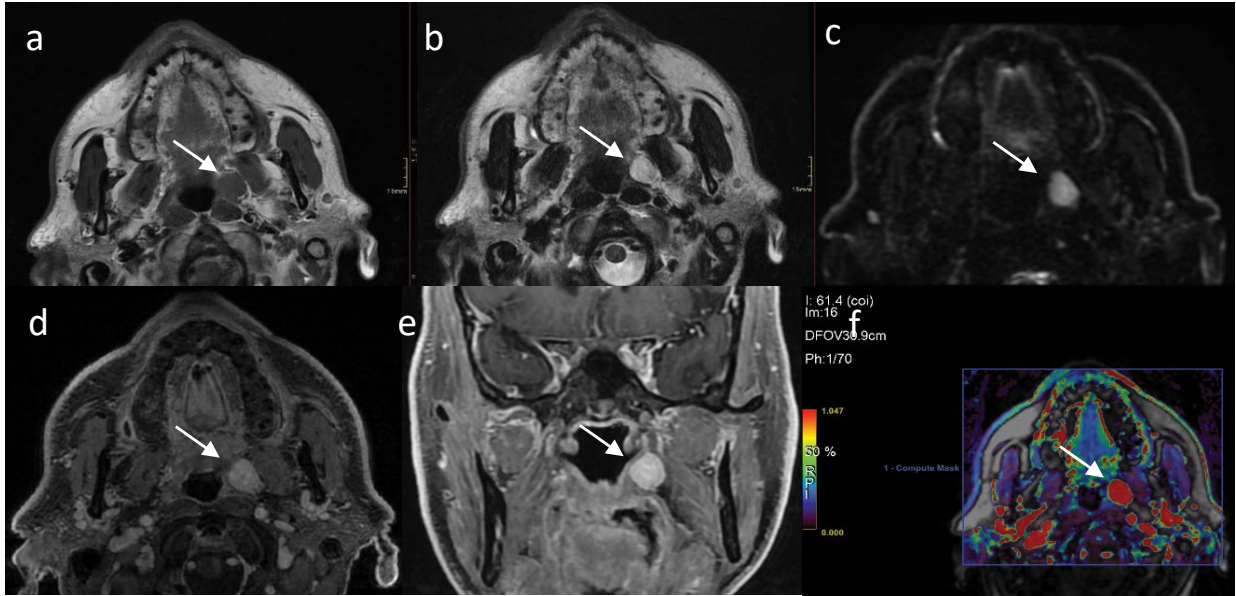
MRI of 66-year-old man. Findings: MRI shows a lesion into the left parapharyngeal space with an expansive growth, with isointense signal on T1 to muscle, hyperintense on T2, with restricted signal on DWI, homogeneous enhancement after contrast medium and high blood and flow volume on perfusion imaging. Technique: MRI at 1.5T, axial plane T1 sequence (a), axial plane T2 sequence (b), axial plane DWI with b 800 (c), axial and coronal planes T1 sequences with fat-suppressed after contrast medium (d-e) and perfusion sequence with Dynamic Contrast Enhanced (blood and flow volume – nIAUGC) (f).
